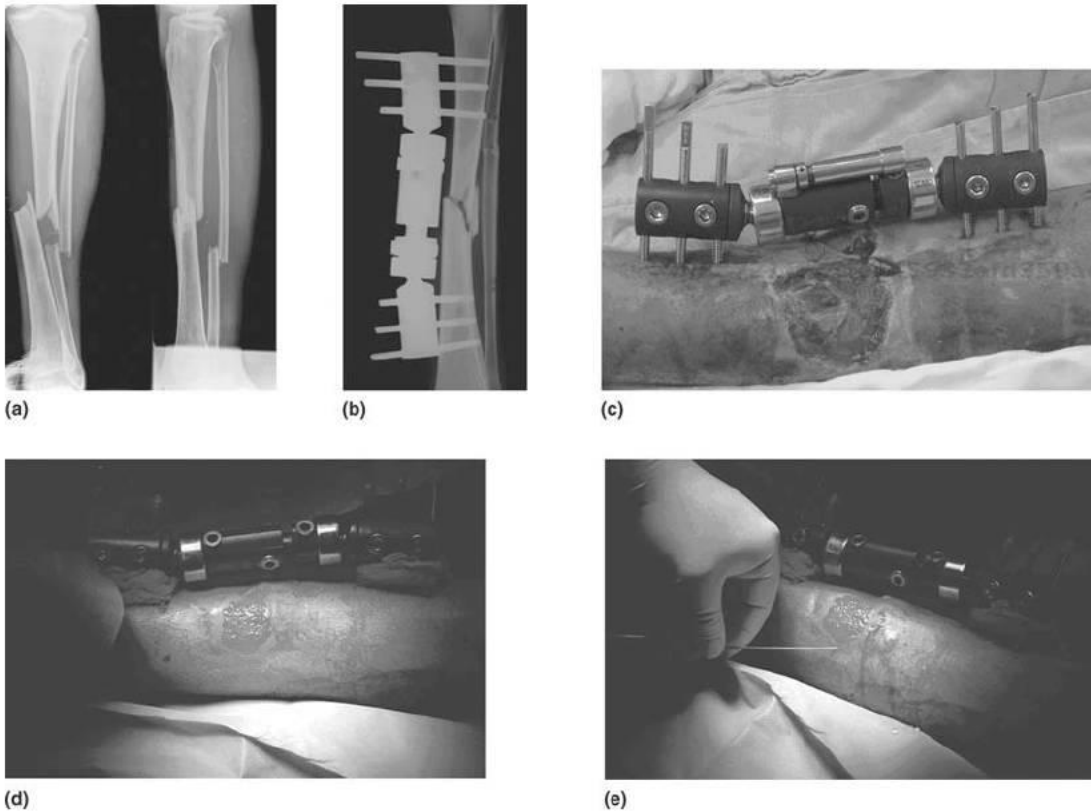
Fractures and surgical treatment. (a) Lateral x-ray of the tibia and fibula fractures. (b) X-ray and (c) photograph showing surgical treatment with placement of monolateral external fixator and coverage of soft tissues. (d) Appearance of the wound after 1 month of wet dressing. (e) Preparation of the implementation of autologous skin. (f) Donor site. (g) Placement of the skin graft taken with dermatome. (h) Graft placed in receptor's site. (i) Final result 2 months after the accident. Courtesy of Eduardo Alvarez, M.D., Ph.D.
